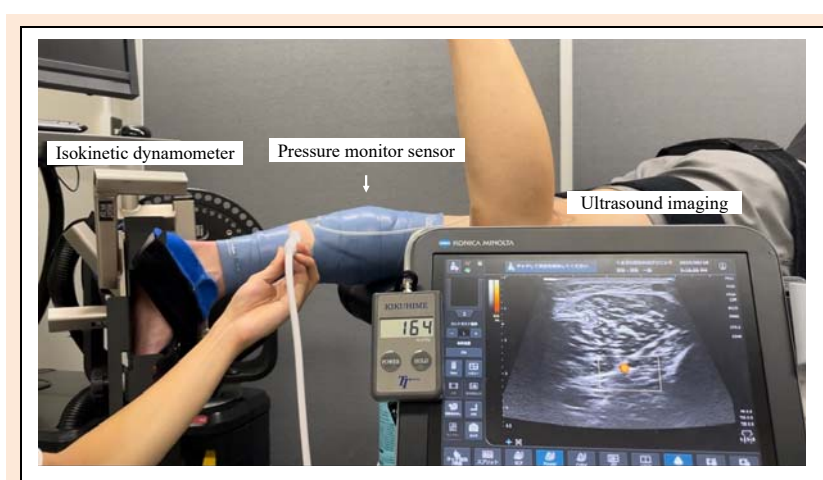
Interventions with tissue flossing bands under conditions of ultrasound imaging observation and pressure measurement. Observation of the short axis of the posterior tibial artery using musculoskeletal ultrasound imaging mounted the 11-MHz linear probe.
